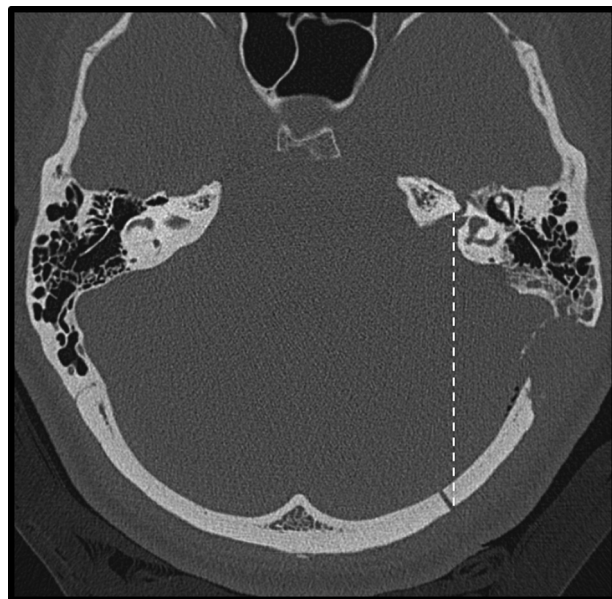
Axial CT scan, right, showing the meato-labyrinthine line, which traces the surgical corridor of the retro-labyrinthine meatotomy, defined posteriorly by the occipital craniotomy, and anteriorly by the petrous bone removal up to the blue line of the superior semicircular canal and the vestibular aqueduct. CT indicates computed tomography.
